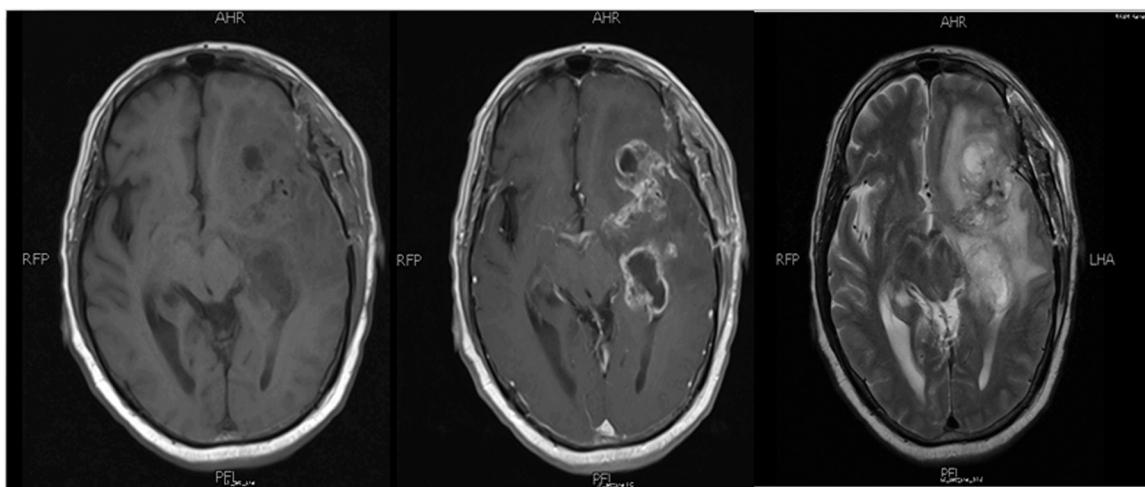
MRI Brain showing significant overall increase in the size of tumor involving the left frontal, temporal and parietal lobes with perilesional edema and post surgical changes in T1, T1 post contrast and T2 weighted images respectively.
